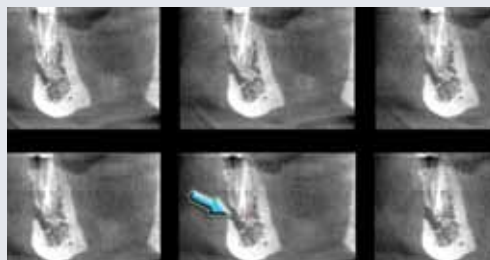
The incalculable diagnostic assist provided by small FOV cbCT speaks to itself as the size and location of the mental foramen and mental nerve canal are revealed.
